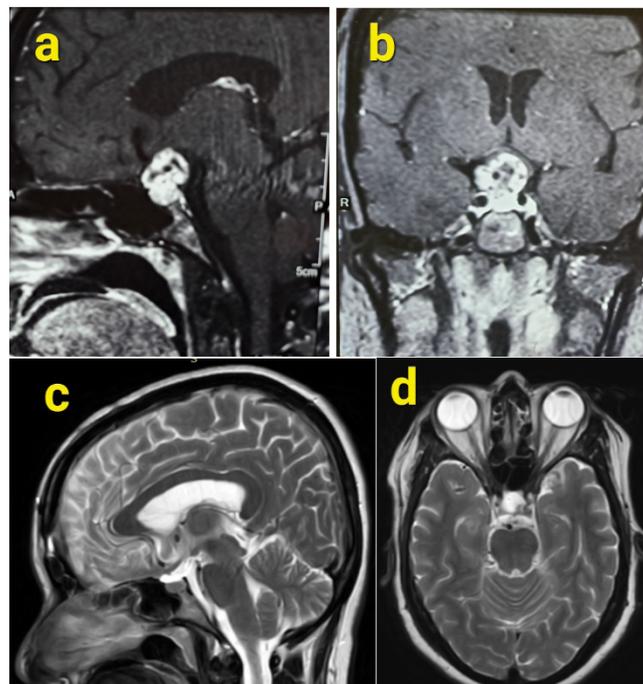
MRI scan of brain
